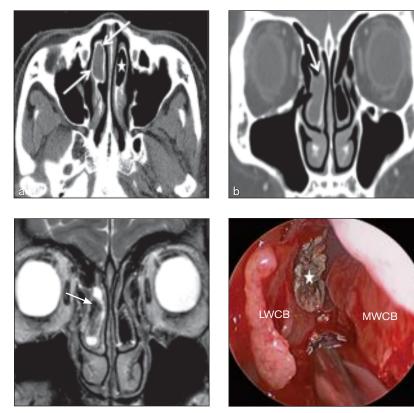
T2-weighted MRI shows a signal void within the concha bullosa (*arrow*).
